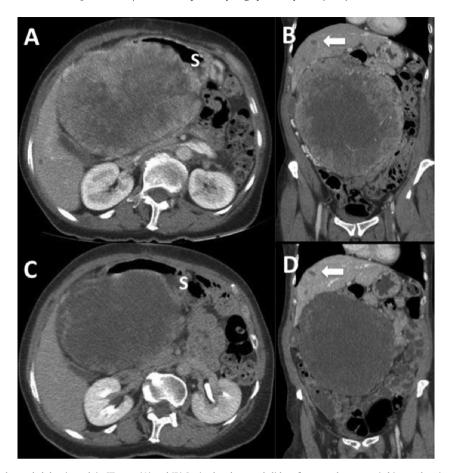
Intravenous contrast-enhanced abdominopelvic CT scan. (A) and (B) Sagittal and coronal slides after open laparotomic biopsy showing a 20 cm abdominal mass with heterogeneous contrast enhancement and central necrosis. Arrow shows liver nodules suspicious of metastases; S denotes stomach. (C) and (D) Sagittal and coronal slides after 10 months of treatment with Imatinib. Note the reduction in tumoral contrast enhancement, a minor decrease in size and stability of liver lesions.
